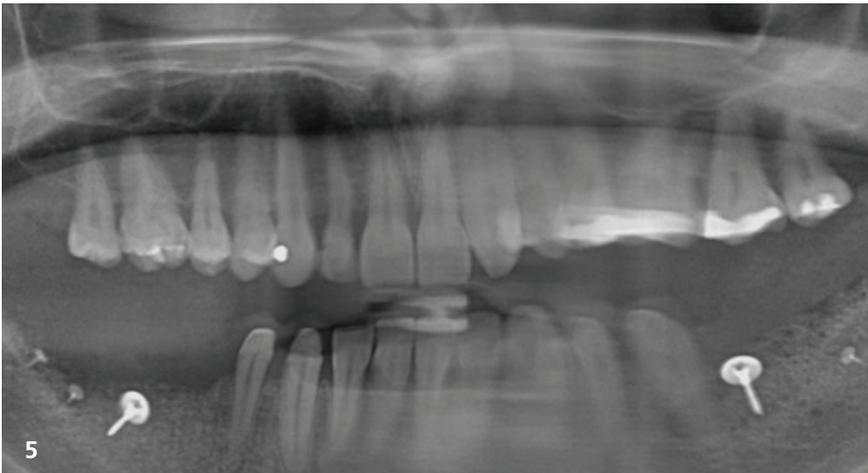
Radiographic view after augmentation. Radiopaque umbrella screws and titanium pins visible.
